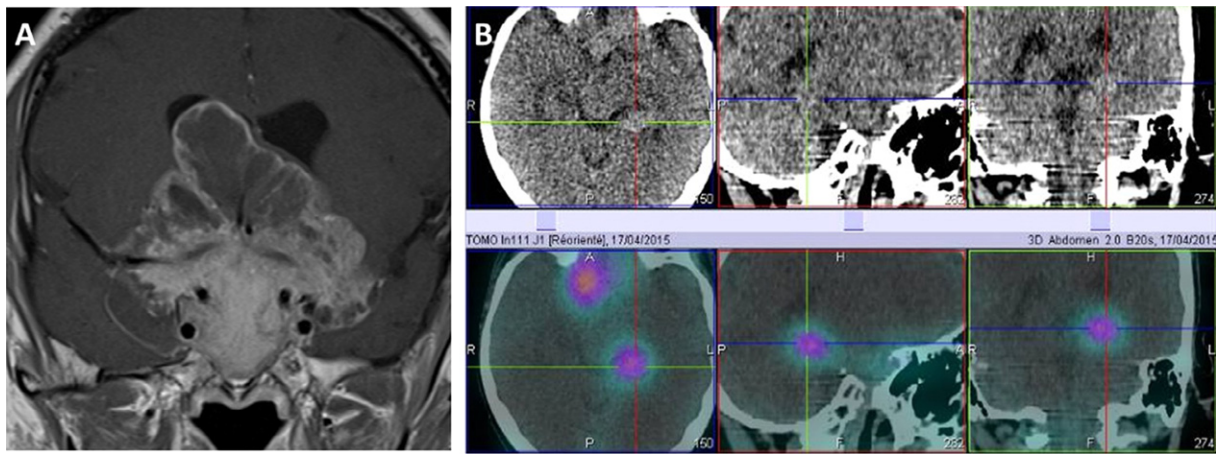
A giant silent corticotroph tumor encompassing both cavernous sinuses, coronal T1 view after gadolinium (A). ^{111}In -DTPA-octreotide scintigraphy imaging demonstrating high uptake in the sella and in brain metastatic deposits in the presence of a growth hormone-secreting pituitary carcinoma (B).
